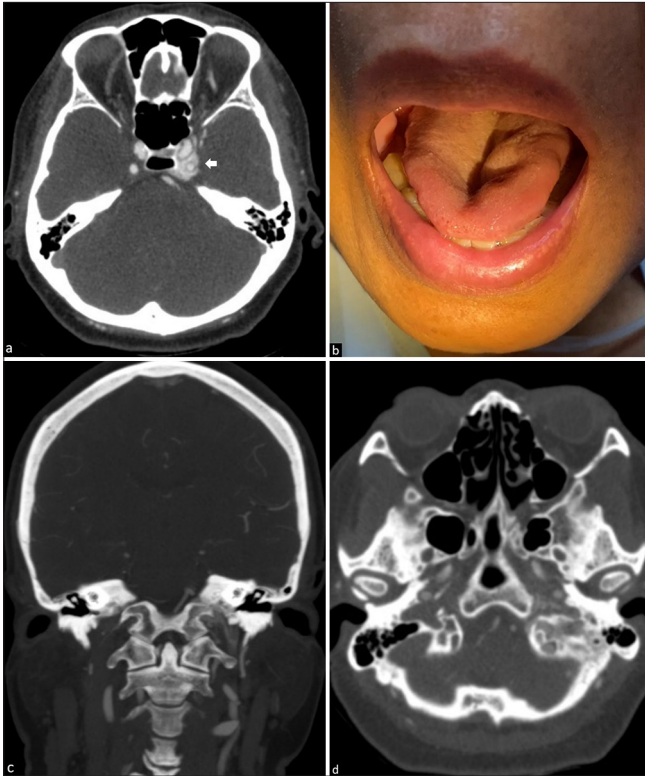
(a) Axial contrast-enhanced computed tomography (CT) scan revealing dilation of the left cavernous sinus (arrow). (b) Clinical photograph showing fasciculations on the left side of the tongue. (c) Coronal and (d) axial CT angiography demonstrate a dilated left anterior condylar confluence and venous plexus within the left hypoglossal canal.
